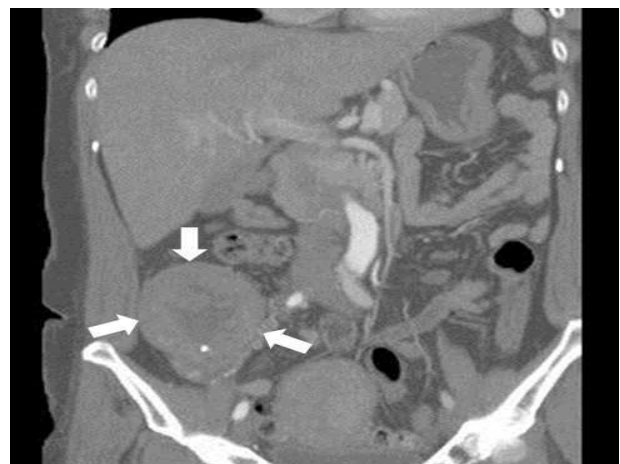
Coronal view of patient's abdominopelvic computed tomography.
